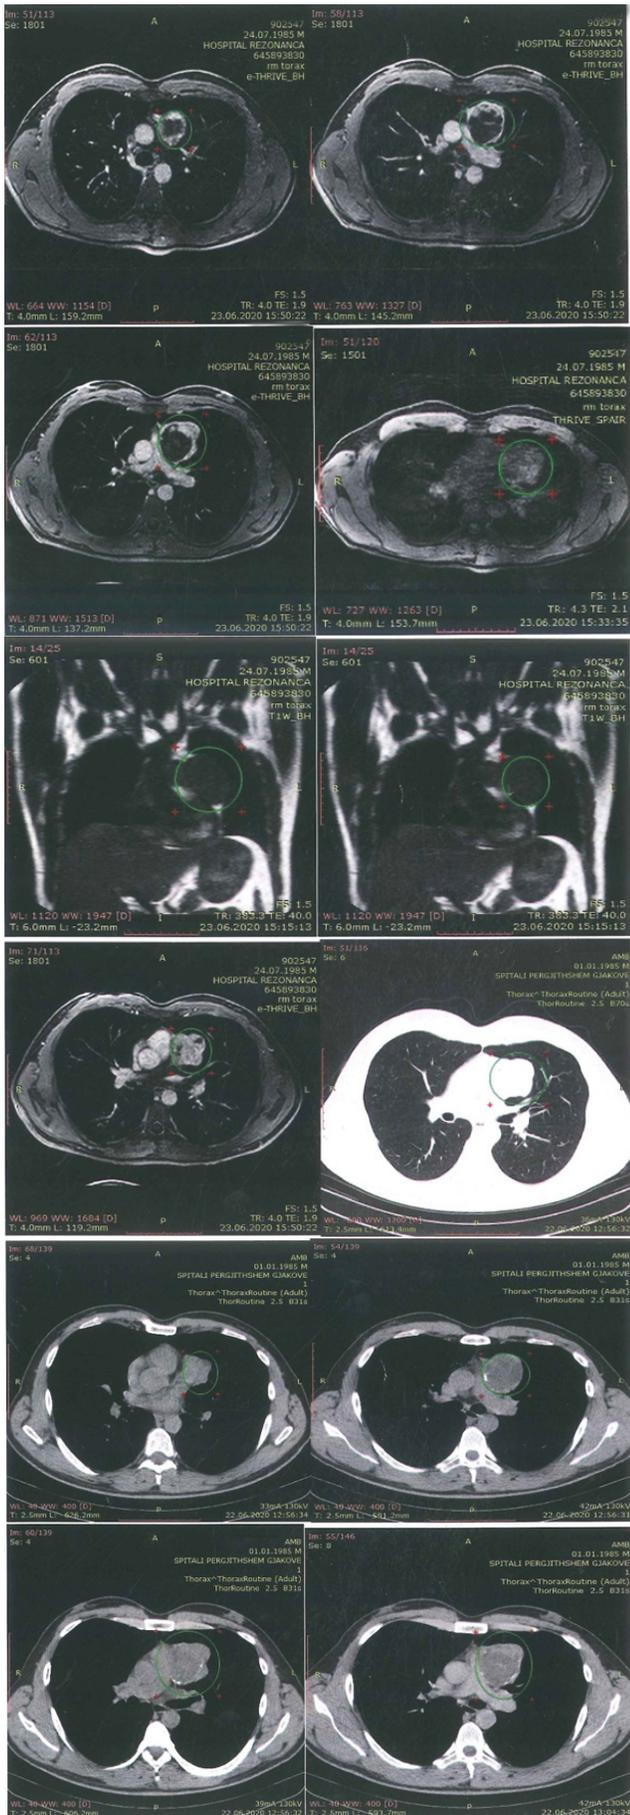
June 2020: Thorax MRI and CT before operation.
